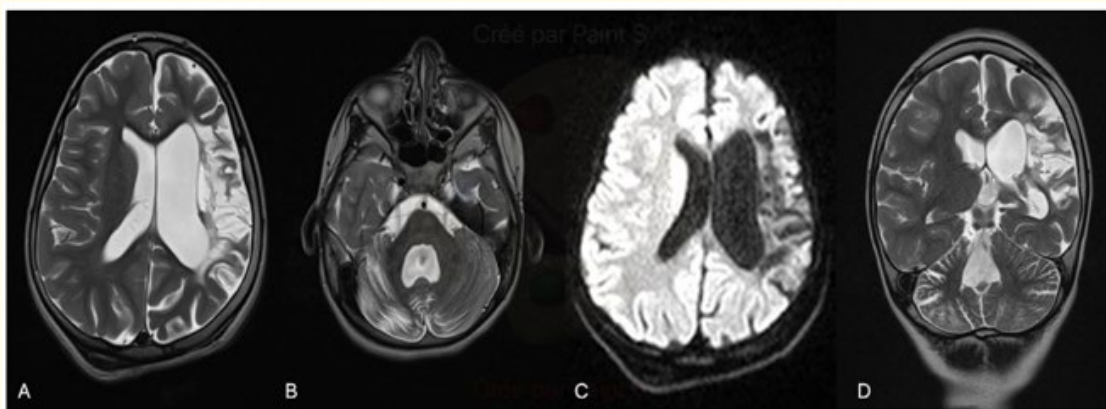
Figure A-D: Figure A and B: Axial T2 on supra and infra-tentorial. Figure C: Axial DWI B1000. Figure D: Coronal T2.
